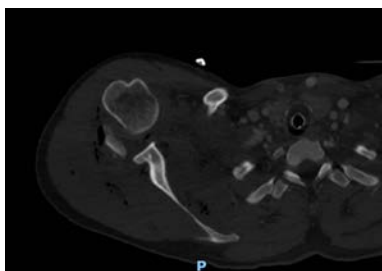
CT reconstructions of the subluxed humeral head and greater tuberosity fragment.
